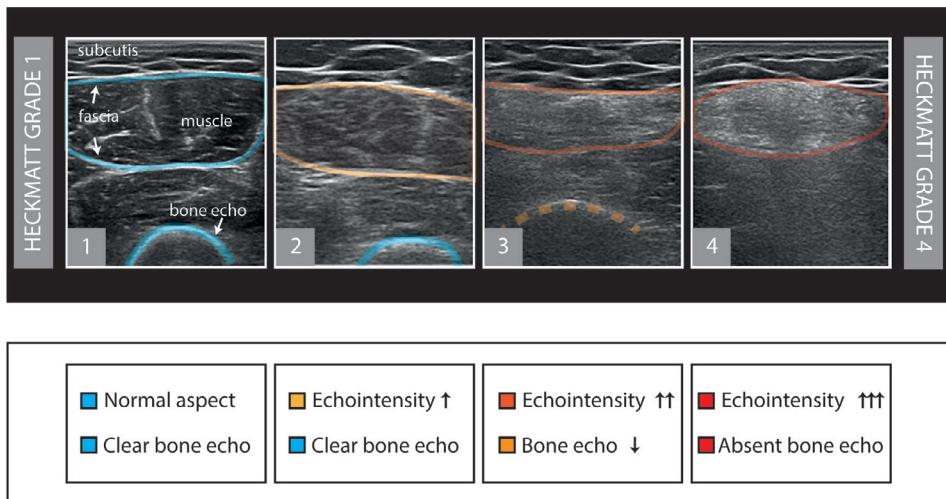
4-point Heckmatt muscle ultrasound grading scale. Grade 1: normal aspect of the muscle. A normal structure of the muscle is seen with a so-called “starry night appearance” with black looking muscle fibers (the black of the night) interspersed with white fascial structures (the stars). There is a clear bone echo. Grade 2: compared to the overlying fat layer, the echo intensity of the muscle is increased. There is a clear bone echo. Grade 3: Marked increased echo intensity of the muscle with diminished bone echo. Grade 4: Very strongly increased echo intensity of the muscle with an absent bone echo due to attenuation of the ultrasound beam in the muscle.
